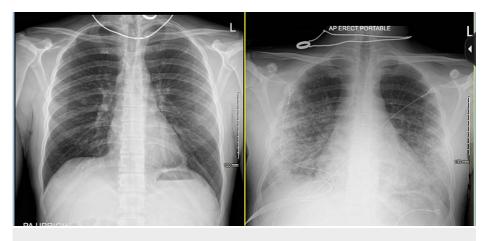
Chest Xrays comparing the day of admission to third day
